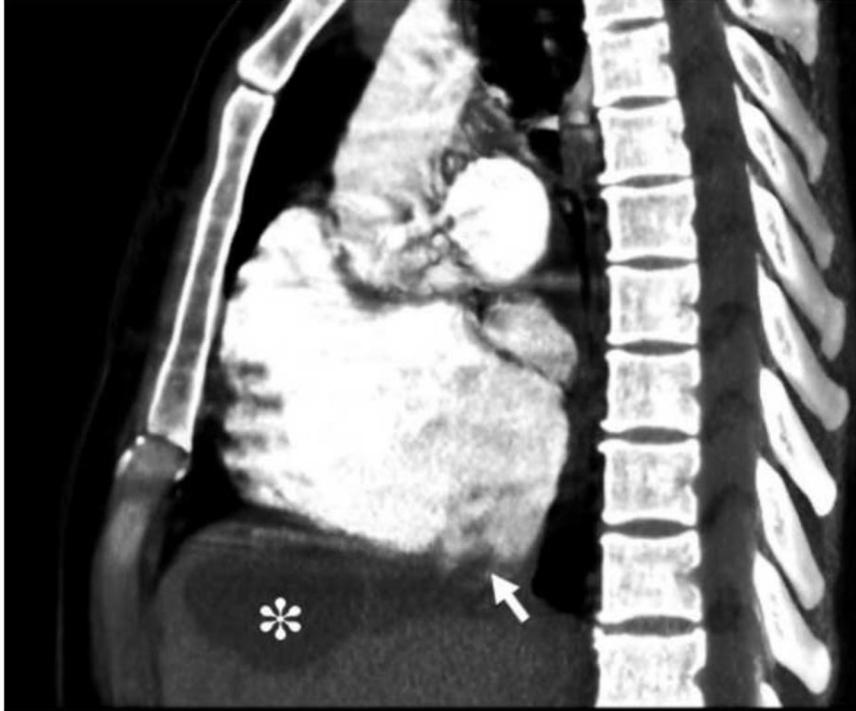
Sagittal maximum intensity projection reconstruction of pulmonary computed tomographic angiography in a 49-year-old woman with hemoptysis reveals a cystic lesion in the liver (asterisk) extending into the inferior vena cava and right atrium (arrow).
